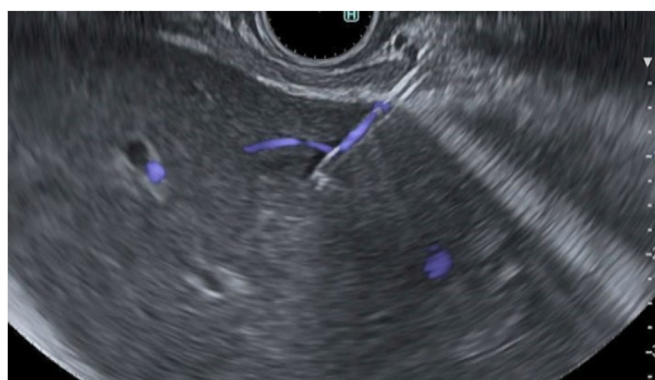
e-Flow Doppler is applied to evaluate for blood in the track. If present, leave needle in the track for a total of 4 minutes to allow blood to clot within the track.
